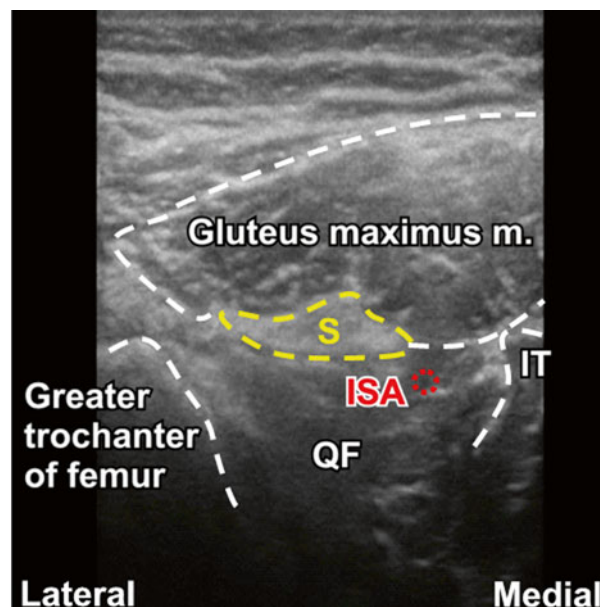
Ultrasound image subgluteal sciatic nerve block location. *S* sciatic nerve, *ISA* inferior subgluteal artery, *QF* quadratus femoris muscle
